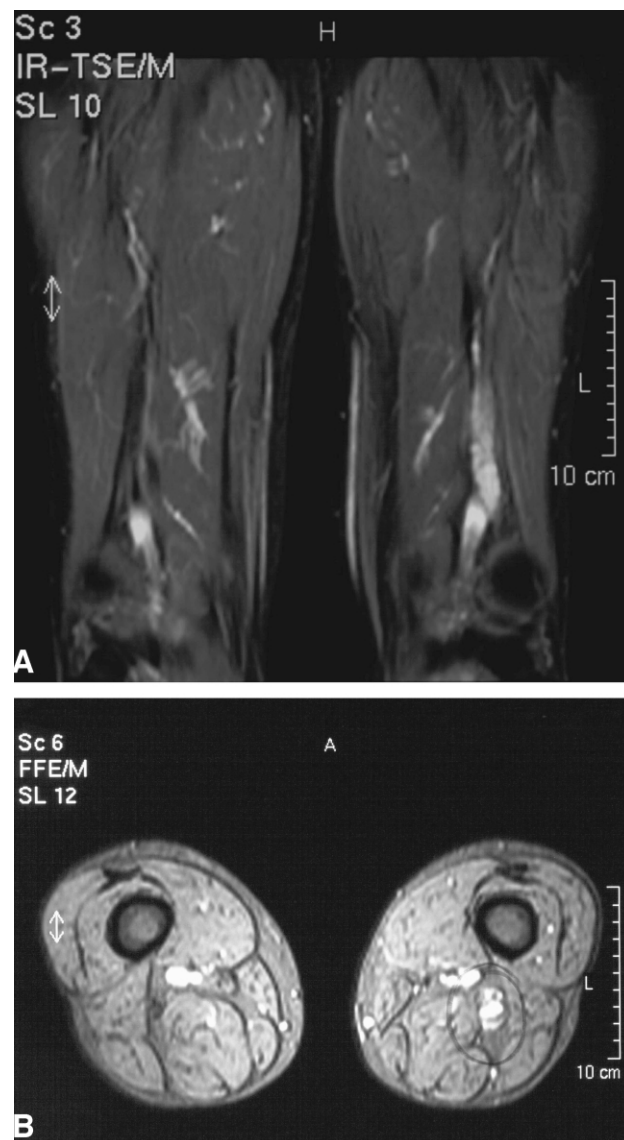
Preoperative (A) coronal and (B) axial MRI slices showing the space-occupying lesion of the left sciatic nerve with fluid content.
